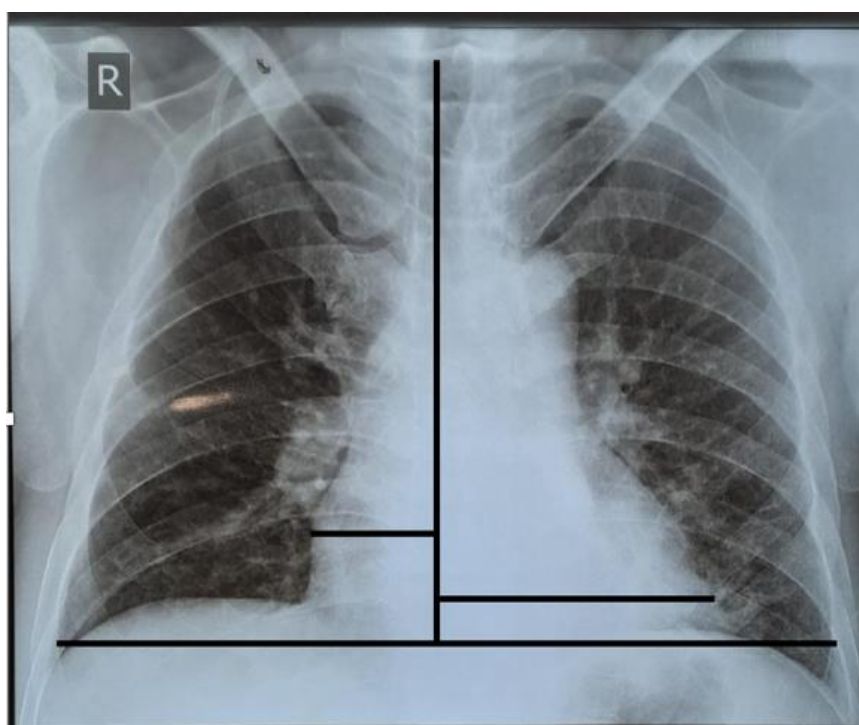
The chest radiograph showed normal results.
